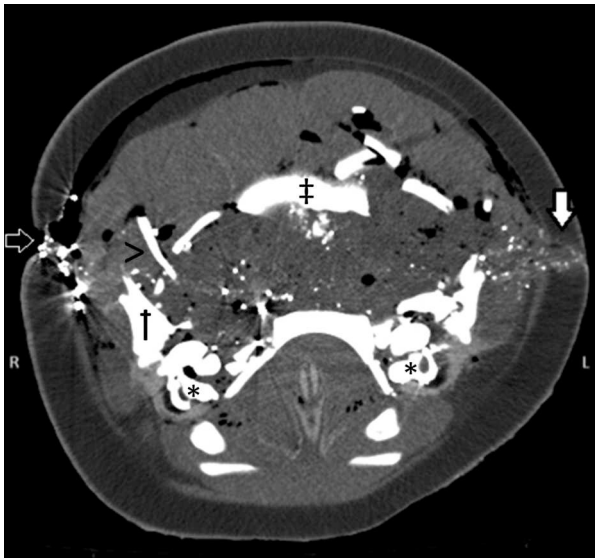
Transverse CT of dusky dolphin (*Lagenorhynchus obscurus*) head, in a soft tissue algorithm with a soft tissue window (window width: 400 HU; window level: 60 HU), showing the entry wound at the right lateral aspect of the head (black arrow), with numerous metal and bone fragments and overall extensive collapse of the calvarium. The white arrow indicates the exit wound along the left lateral aspect of the head with a trail of small metallic and bony fragments extending to the surface. The tympanic bullae (*), temporal bone (†), parietal bone (>) and occipital bone (‡) are indicated.
